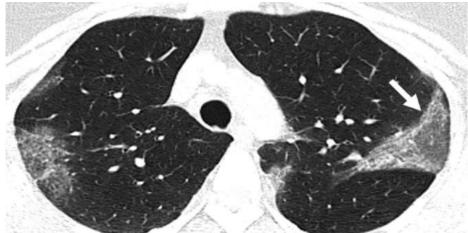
showed CT scan of a lung infected with Corona virus19
